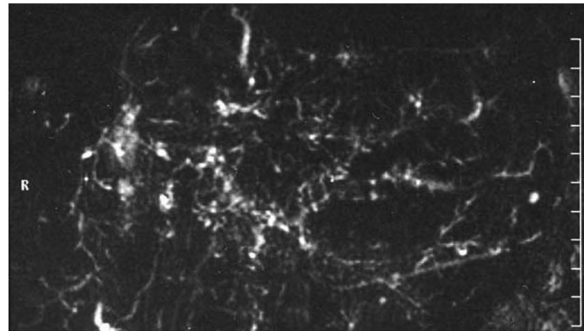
Representative radiologic image of Recurrent Primary Sclerosing Cholangitis following living donor liver transplantation. Drip infusion computed tomography cholangiography obtained from a typical recurrent case. Note the multifocal strictures and beading of the bile ducts within the engrafted partial liver.
